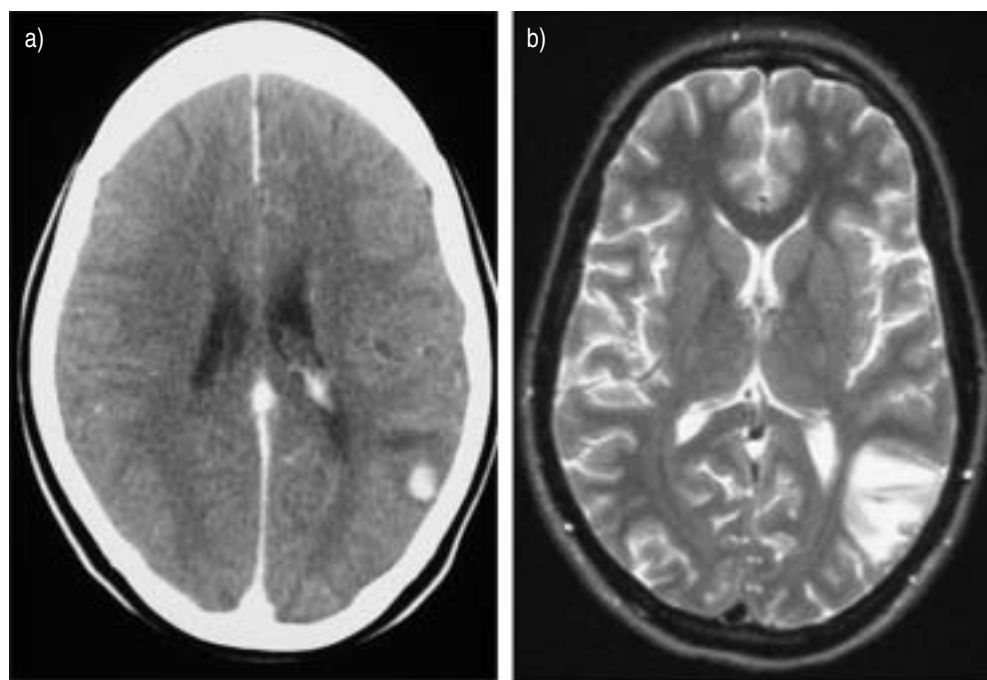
Post-contrast images showing a left parieto-occipital enhancing lesion in case B: a) computed tomography; and b) T2-weighted magnetic resonance imaging.
